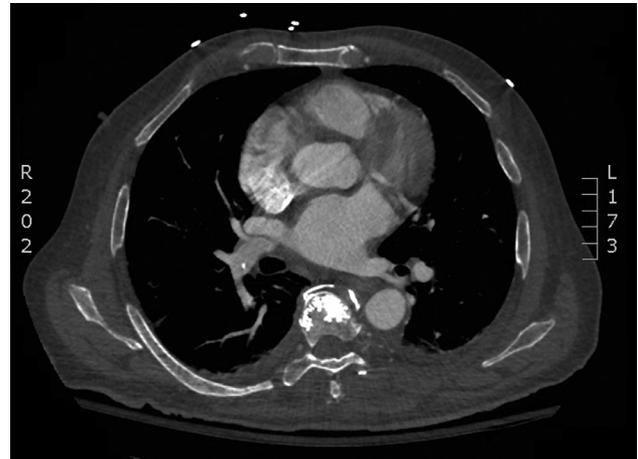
Axial CT scan cut evidencing PMMA within the segmental vertebral vessels of the same patient.
